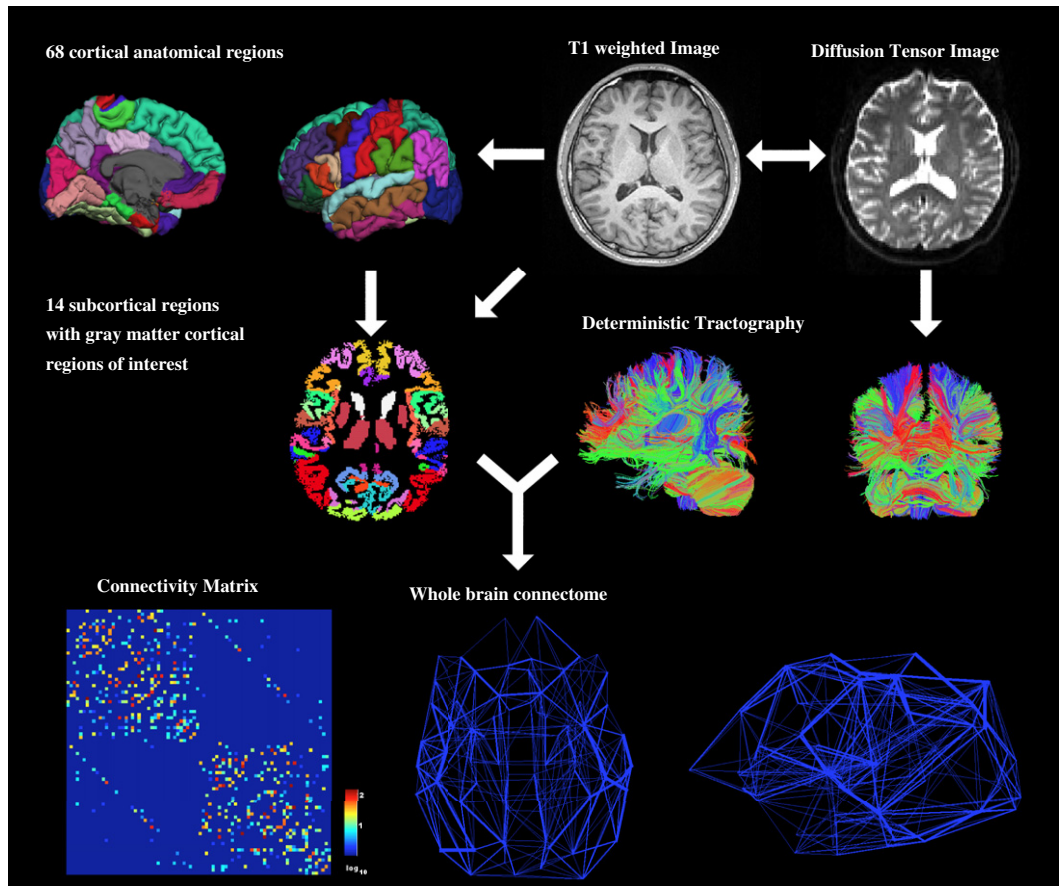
Overall procedure. From T1-weighted images, we generated 82 regions of interest (ROIs, 34 cortical areas and 7 subcortical areas a hemisphere, on the left). From diffusion weighted images, we reconstructed streamlines using deterministic tracking (on the right). Combining these two pre-processing steps, we constructed a weighted network where weights are determined by the number of streamlines connecting two ROIs.
